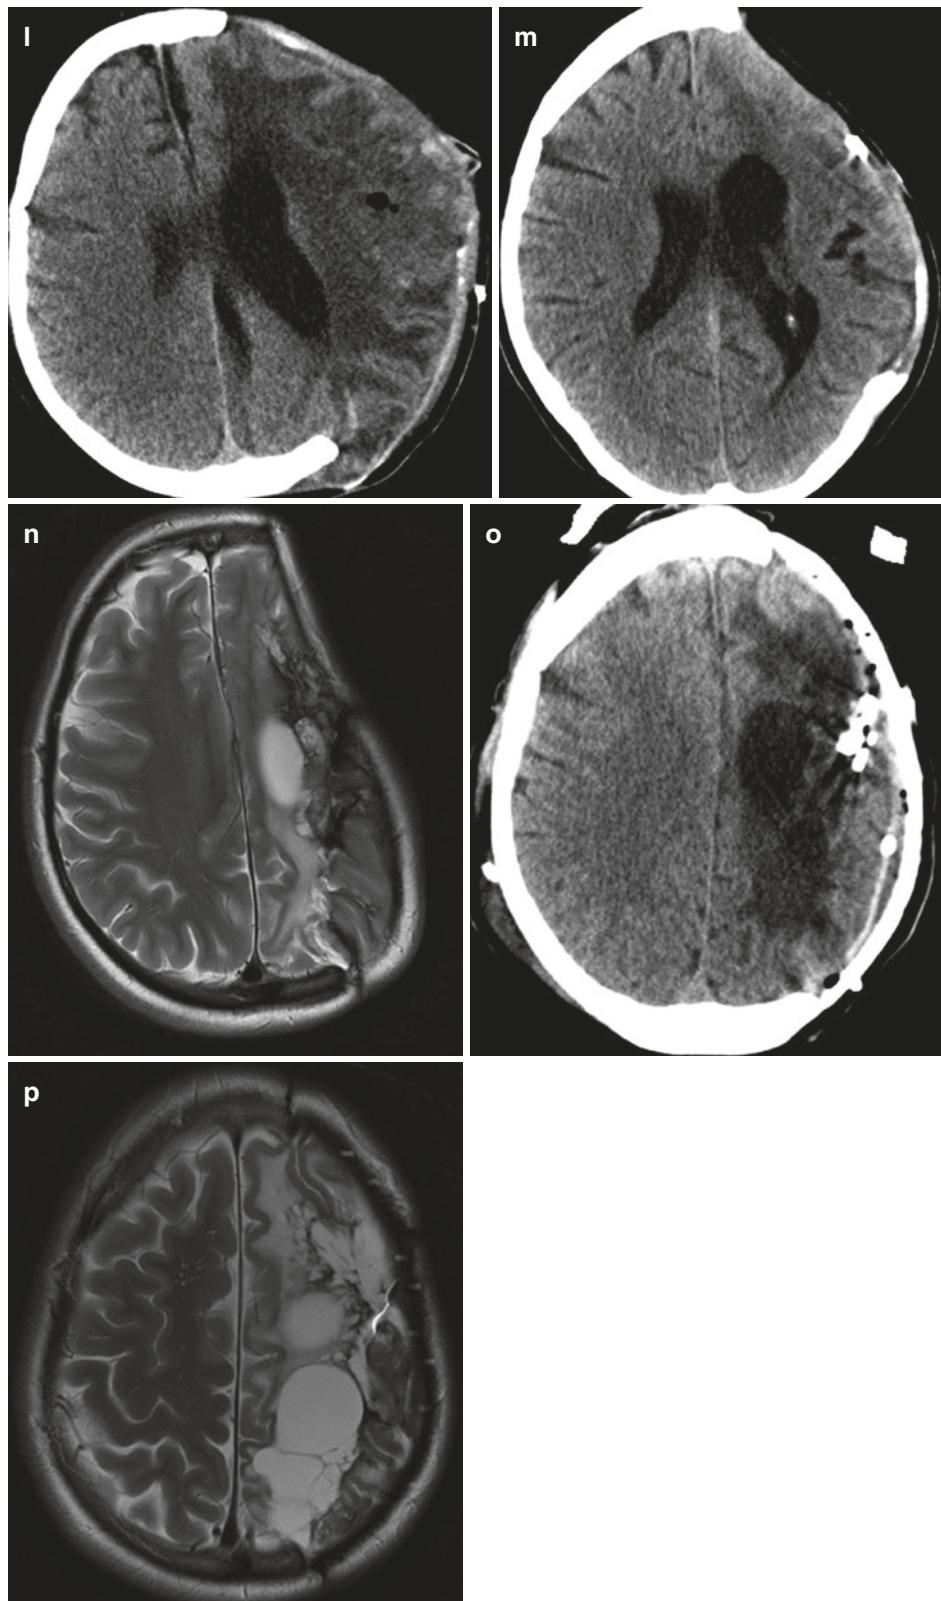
My worst case. Left frontal AVM SM II. (a) MR, (b–e) Angiography, (f) CT immediately after the surgery, (g) CT the next day, (h) After the decompression the same day, (i) CT a week later, (j) CT after another week and after malacic tissue resection, (k) angiogram 1 month
